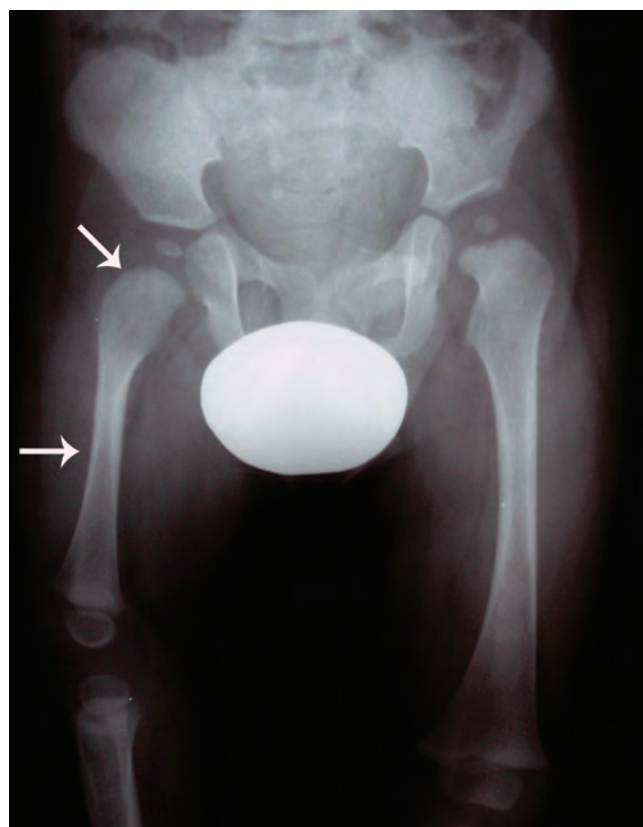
Anteroposterior radiograph of Case 2, 12 months after initial radiograph. Ossification centers of femoral heads are visible on both sides. Substantial improvement in development of right femur is observed (white arrows). Acetabular angles are within normal range on both sides.
